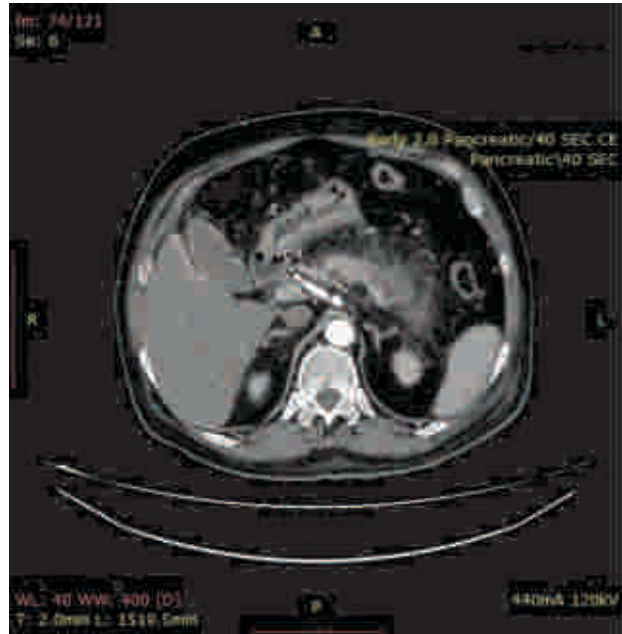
Contrast Enhanced CT Abdomen Showing Necrosis in Head and Body
